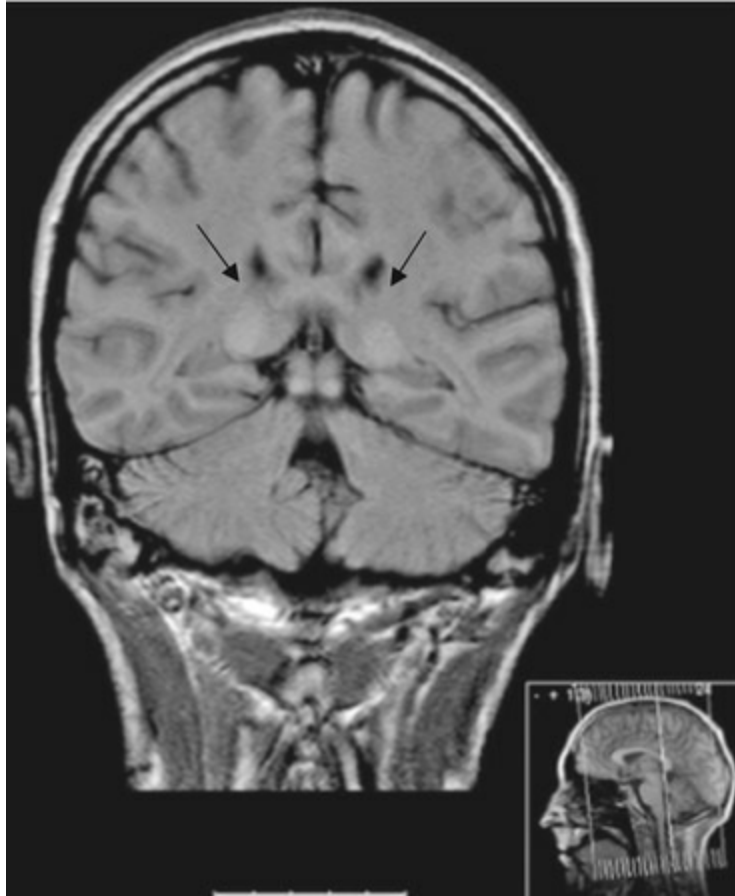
High signal in the pulvinar (*arrowed*) in Fabry disease: T1-weighted coronal MRI section
